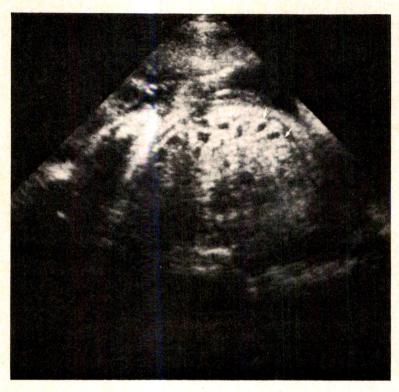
Frame from real-time sonogram shows a cross section of the fetal abdomen with multiple bowel loops. Note that the bowel wall is well seen from either side (arrows).
